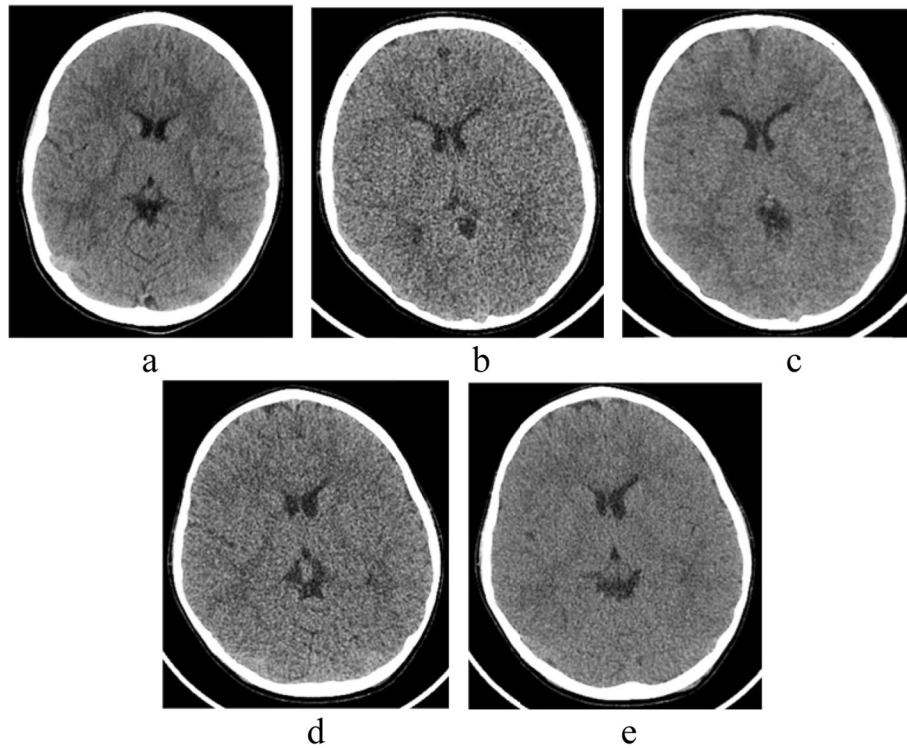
Image quality of CT images at the level of thalamus. Non-ASIR CT image (a), 60% ASIR-V (b), and 80% ASIR-V (c) CT images using 80-mA tube current reduced CT protocol, and 60% ASIR-V (d) and 80% ASIR-V (e) CT images using 100-mA tube current reduced CT protocol
